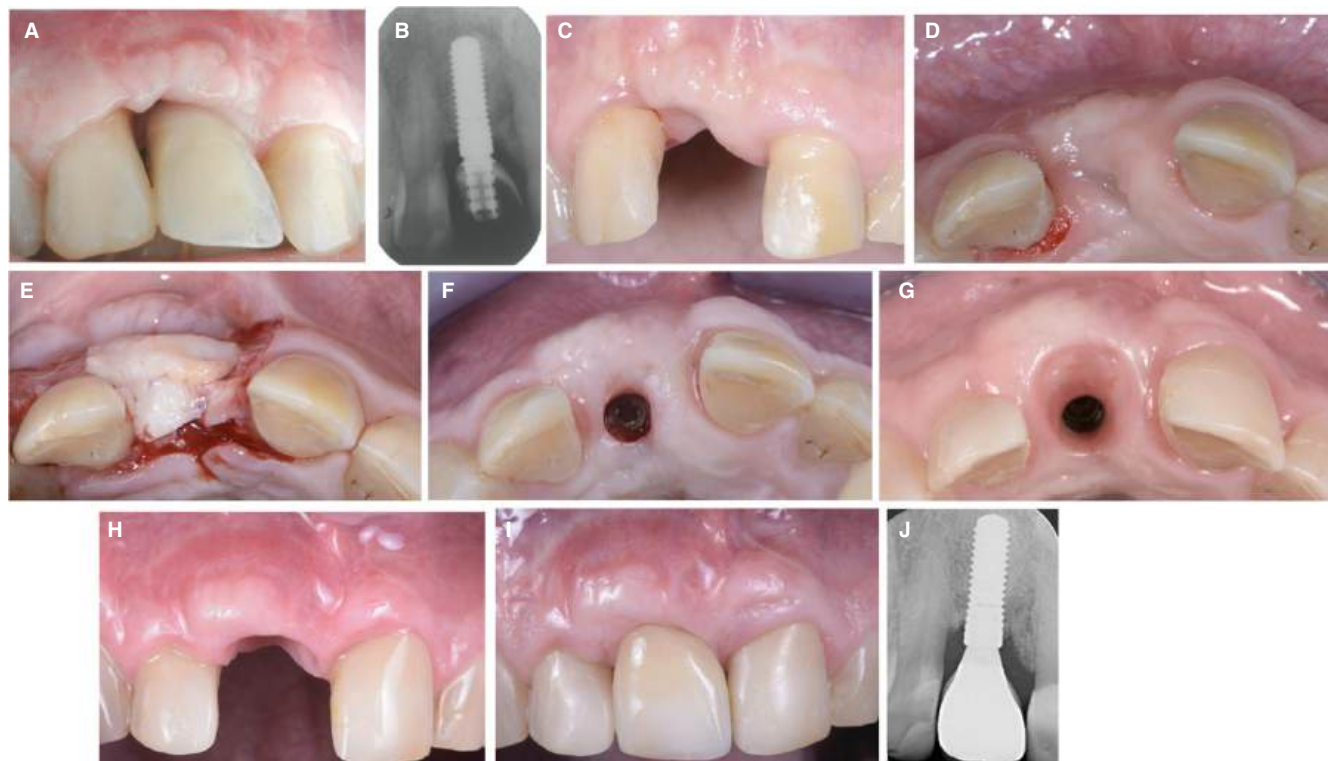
Soft tissue dehiscence. A, Buccal view showing the soft tissue dehiscence with a lack of the distal papilla. B, Baseline radiographic situation. C and D, Soft tissue maturation after crown and abutment removal. E, Connective tissue graft sutured at the connective platform. F, Four months of healing and exposure of the head of the implant. G and H, Soft tissue healing after conditioning. I, Final restoration delivery. J, Radiographic control
